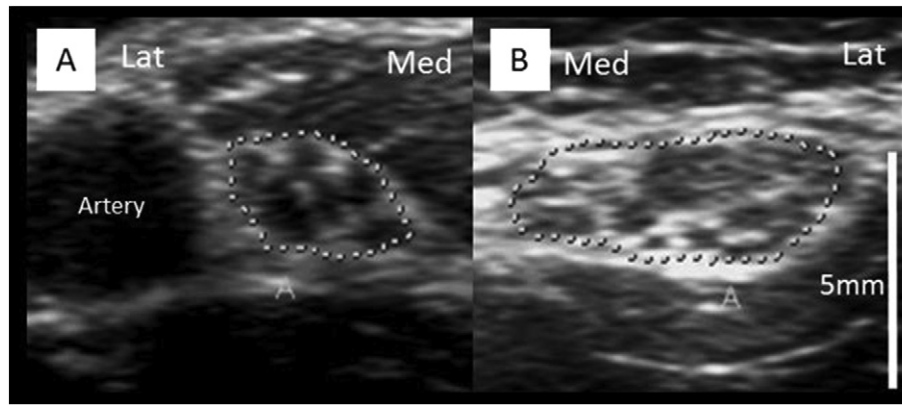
Ultrasonograms of patient 1 showing side-to-side comparisons of the median nerve (circled). A: The 9-mm² non-affected side (right arm) vs. B: cross-sectional area of the 18-mm² affected side (left arm), in the region 5 cm proximal to the elbow. Lat: lateral, med: median.
